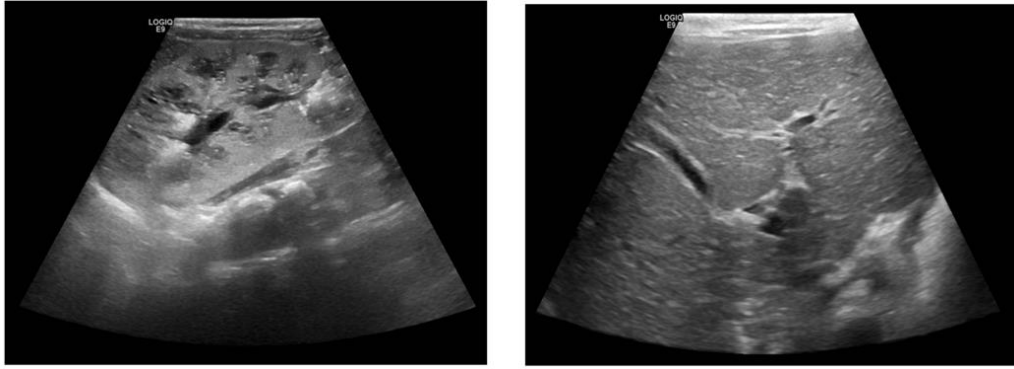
Ultrasound abdomen results of the proband. Kidney ultrasonography showing enlarged kidneys (right kidney 8.2 cm in length) (left panel). Liver ultrasonography shows mild dilatation of intrahepatic ducts (duct diameter 3 mm) but no cystic dilatation of biliary tree (right panel).
